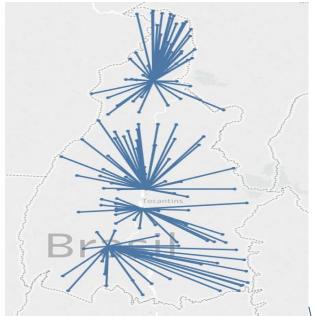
Geographic map of population displacement for Dual Energy X-ray Absorptiometry (DXA) examination in the state of Tocantins-TO.
